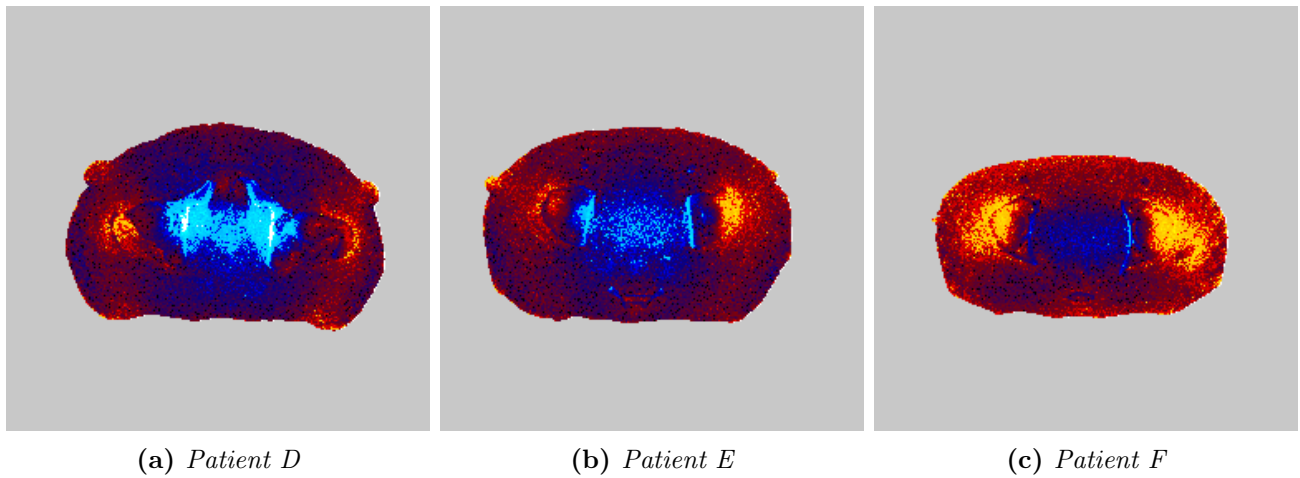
Transversal slices of the relative difference for all pelvis patients for a CBCT acquisition (360° tube rotation). Note the common pattern of under- and overestimation of the dose for all of the patients. The colorscale for this plot is the same as for the CBCT acquisition in the head and neck area and is shown in Figure 9.24a.
